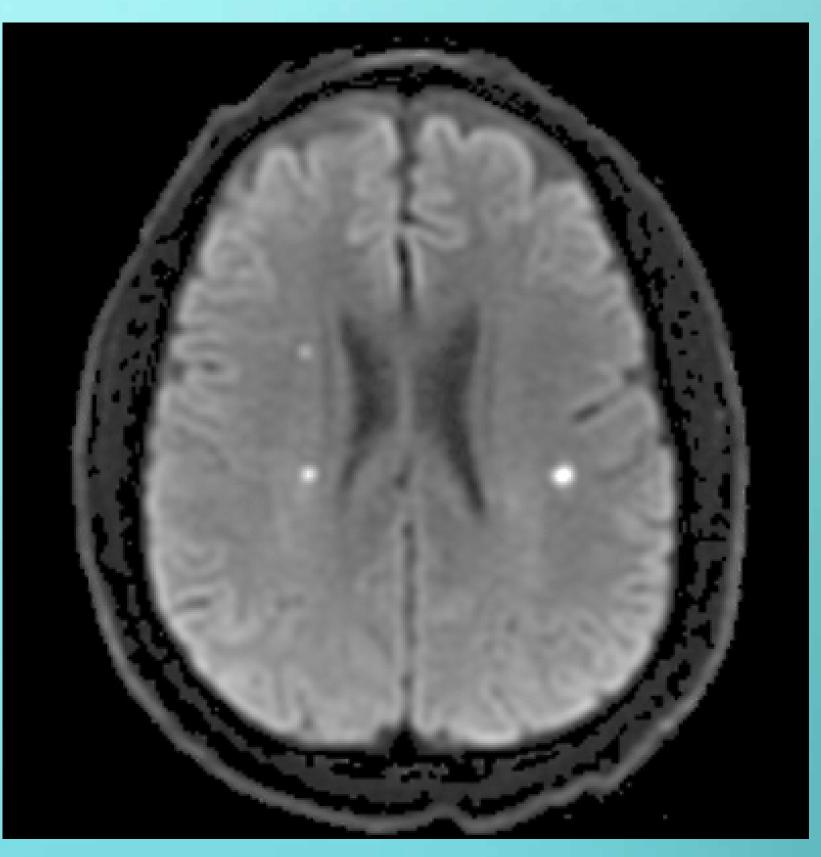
Repeat MRI of the Brain which revealed two of the three new infarcts in the right frontal lobe and basal ganglia.
